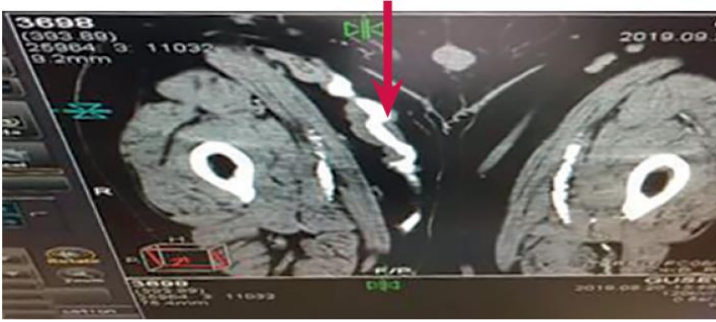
Computed tomography with contrast enhancement of femoral upper third. Multiple aneurysmal deformity of the autovenous femoral-popliteal bypass (arrow)
